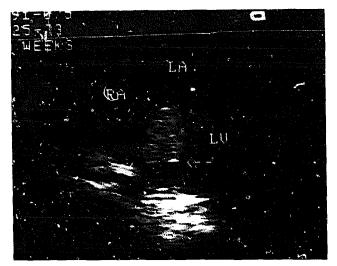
Fetal echocardiographic four-chamber view recorded at 32 weeks shows a single, large homogeneous rhabdomyoma in the interventricular septum (arrow). LA = left atrium; LV = left ventricle; RA = right ventricle.
